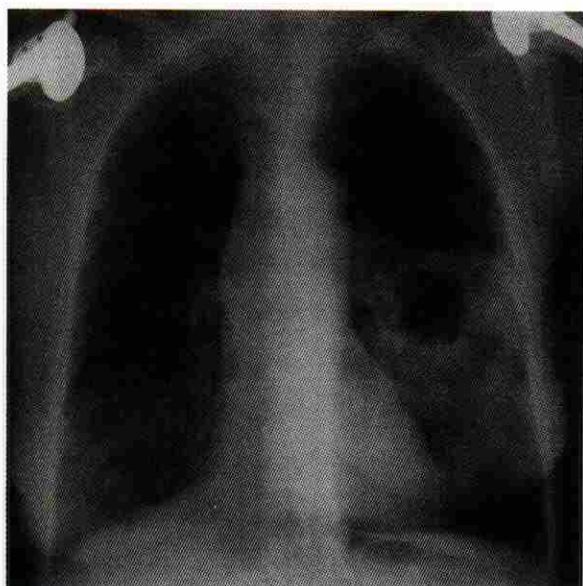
Chest radiograph of patient with cavitating staphylococcal pneumonia. Note left lower lobe consolidation with large cavity and air-fluid level.
